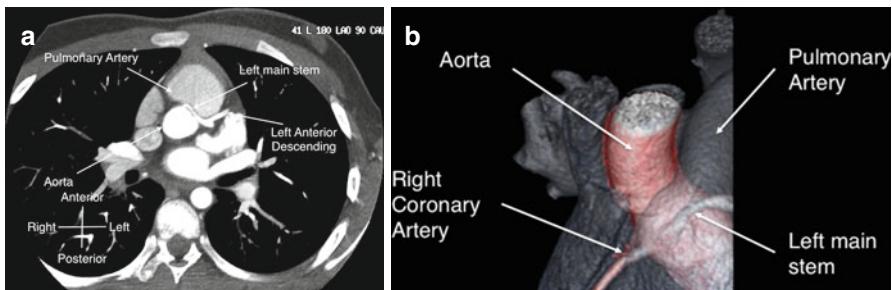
(a) Transverse slice from CT demonstrating left main coronary artery arising from anterior (right coronary) sinus and coursing between aorta and pulmonary artery. (b) CT reconstruction of aortic root. The aorta is coloured red and the pulmonary artery grey. The left coronary is seen emerging acutely from the right sinus and then coursing between the great vessels
